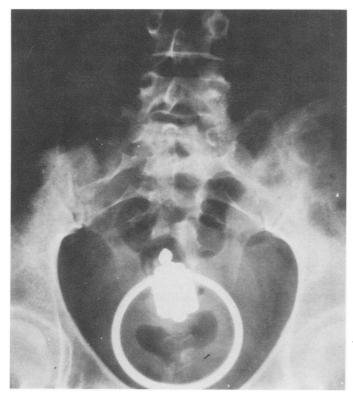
X-ray of female patient with vibrator in rectum and diaphragm in vagina.
